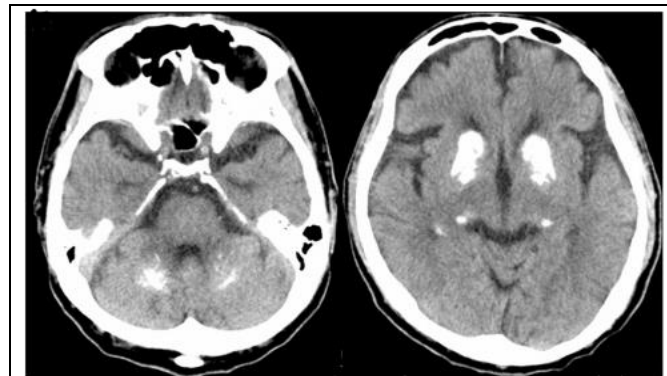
The basal ganglia, thalamus, and dentate nucleus all showed symmetrical calcification on the brain computed tomography (CT) scan, with a marginally increased calcification area.
